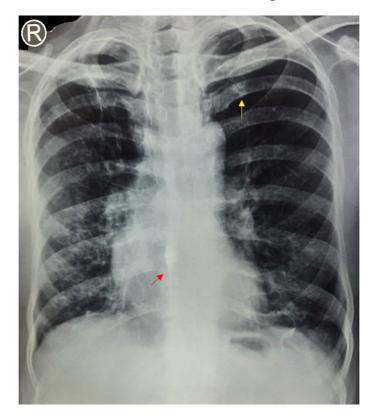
X-Ray Chest PA view showing fracture of posterior end of left fourth rib with bone sclerosis (Yellow arrow) and another area of density overlying D8 and D9 (Red Arrow).
